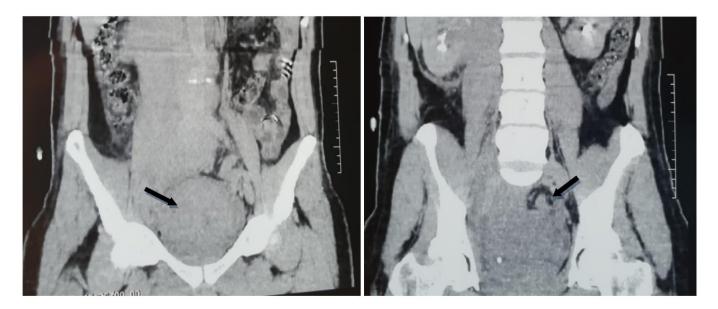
A frontal section of a pelvic abdominal Computed tomography scan showing bladder thickening and a locally advanced bladder tumor
